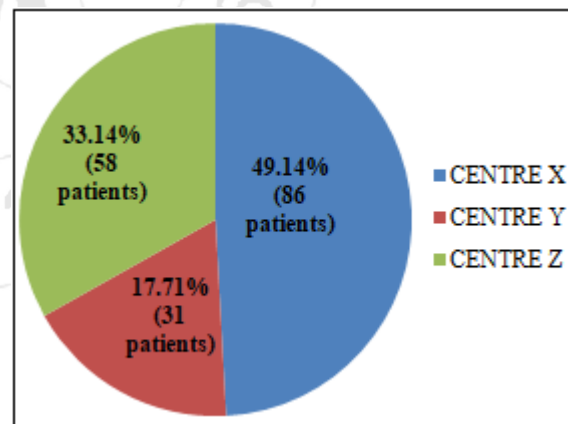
The patients' abdomen computed tomography population distribution
